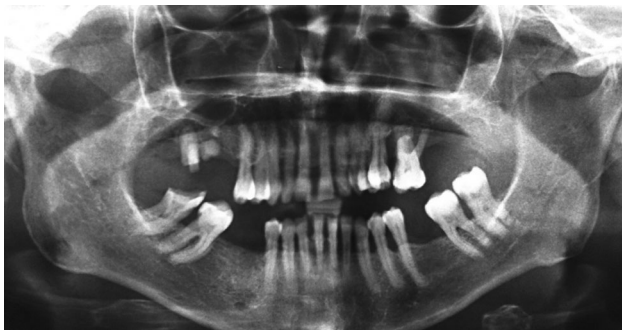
A panoramic radiograph revealing cause of abscess
